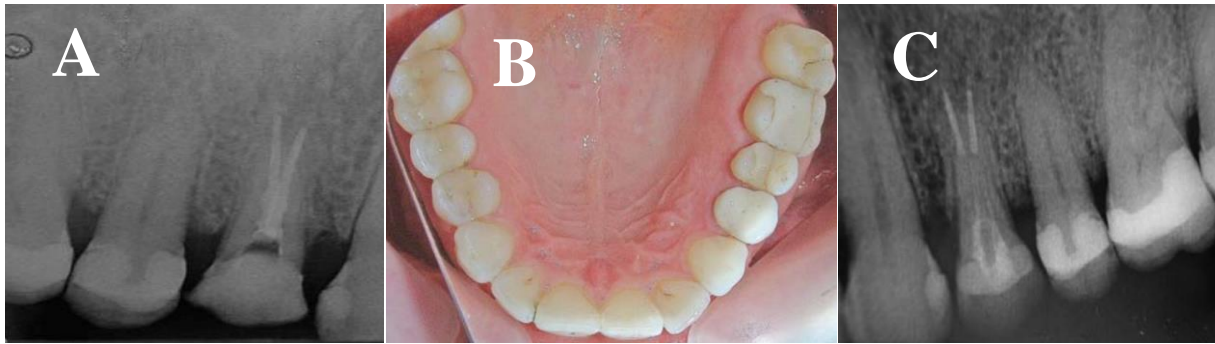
(Bielicka *et al.*, 2008). A 35-year-old patient was referred presenting dental injury in the upper left premolar tooth. Clinical examination revealed the crown fracture with remaining only buccal part of crown. The fracture line was located subgingivally in the level of alveolar crest at the palatal and mesial aspect and extending 2 mm supra-gingivally at the distal aspect. (A): The radiographic examination confirmed the clinical findings and also revealed that the tooth was earlier treated endodontically. In such case, due to subgingival location of the fracture line, there was not possible to properly prepare the root in order to made a post and core. Therefore, treatment plan was orthodontic treatment to extrude the dental root and move the fracture line above the alveolar bone. Then the tooth was restored prosthodontically, with a post and core, and porcelain crown. (B): Palatal view after prosthetic restoration of tooth. (C): Radiographic view of the tooth after cementation of post and core and ceramic crown.
